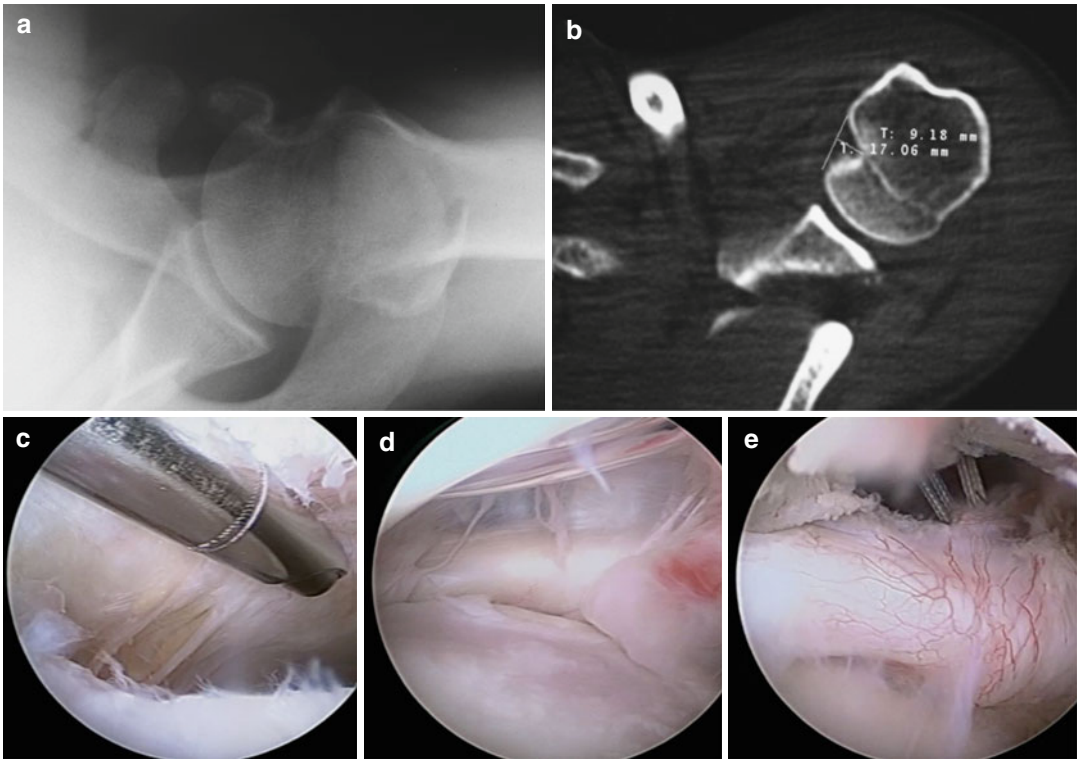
Reverse Hill-Sachs lesion on x-ray (a), CT scan (b), and arthroscopic view (c, d). Arthroscopic reverse remplissage procedure (e)
